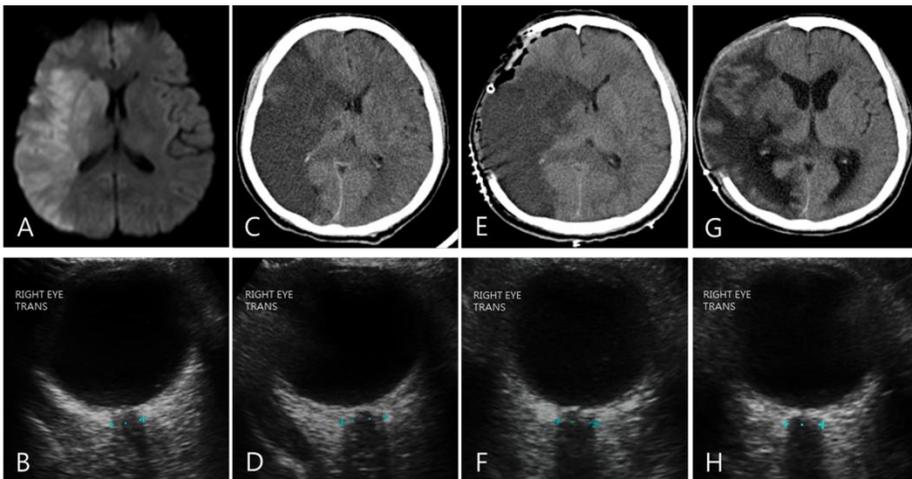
A and B, A 57-year-old man presented with left hemiparesis because of acute middle cerebral infarction on the right side seen on diffusion magnetic resonance imaging. Optic nerve sheath diameter (ONSD) on the right side was measured at 5.2 mm. C and D, The level of consciousness decreased to drowsy on the 2nd day with aggravation of cerebral edema seen on brain computed tomography (CT). ONSD on the right side increased to 6.3mm. E and F, Decompressive craniectomy decreased midline shift with ONSD of 5.8mm. G and H, CT scans taken after 2weeks after operation showed a substantial improvement in the extent of midline shift with ONSD of 5.4mm.
